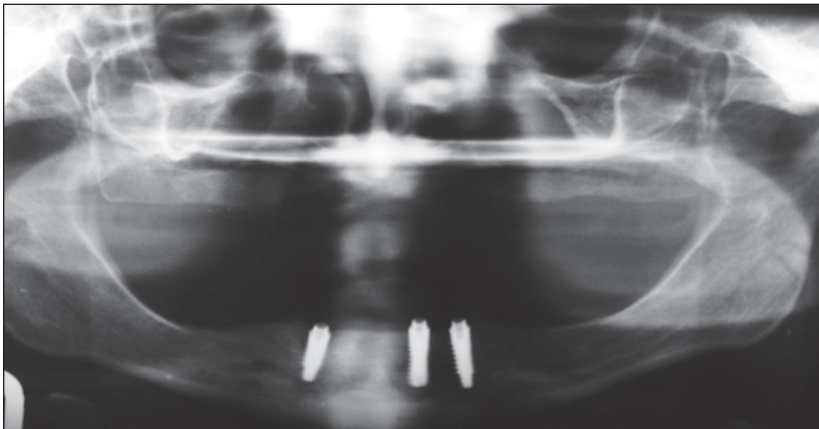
Panoramic radiograph 1 week after the placement of the implants.
